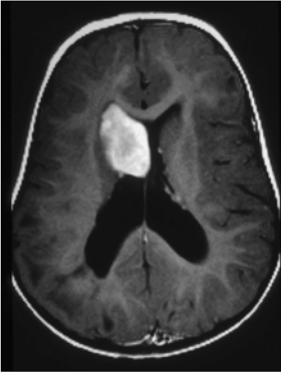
Contrast-enhanced axial MRI scan demonstrating a well-circumscribed tumor in the lateral ventricle.
